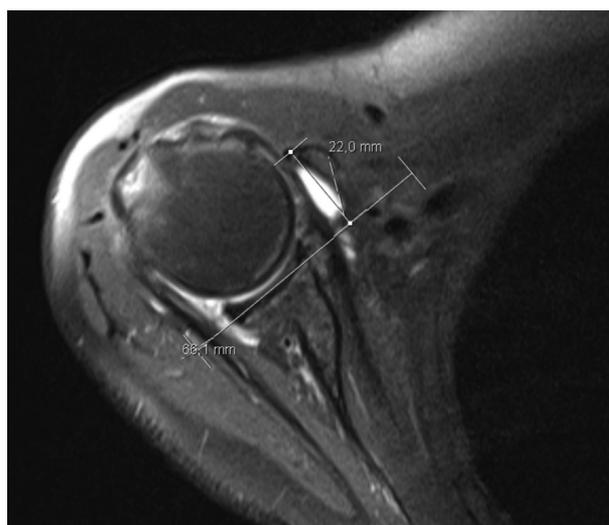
Transverse section of T1-weighted magnetic resonance image showing coracoid overlap—distance from glenoid to tip of coracoid process.
